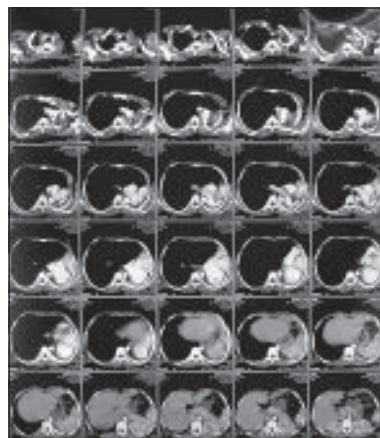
Pulmonary aplasia: Same patient. Mediastinal window CT slice reveals marked displacement of heart and major vessels into the left hemithorax due to absence of pulmonary parenchyma.*
